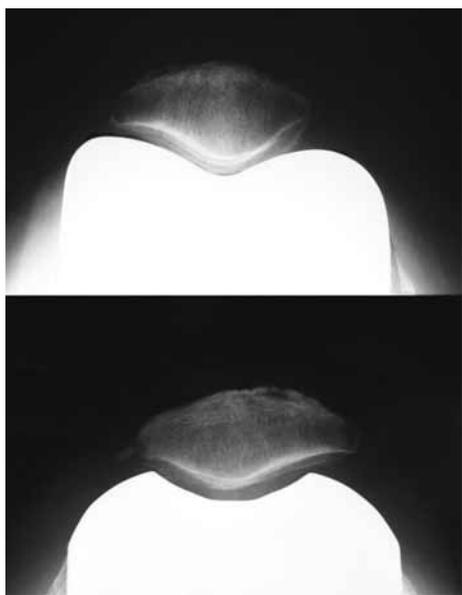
Postoperative radiographs (Merchant's view) showing a 'patellar-friendly' anatomic femoral component (top) and a patellar unfriendly femoral component (bottom), both articulating against the native patella.
